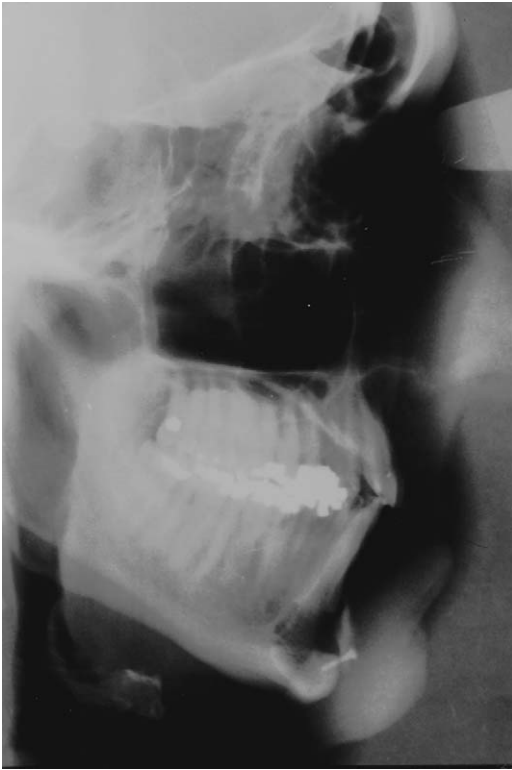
Lateral cephalometric radiograph before maxillo-mandibular advancement.
